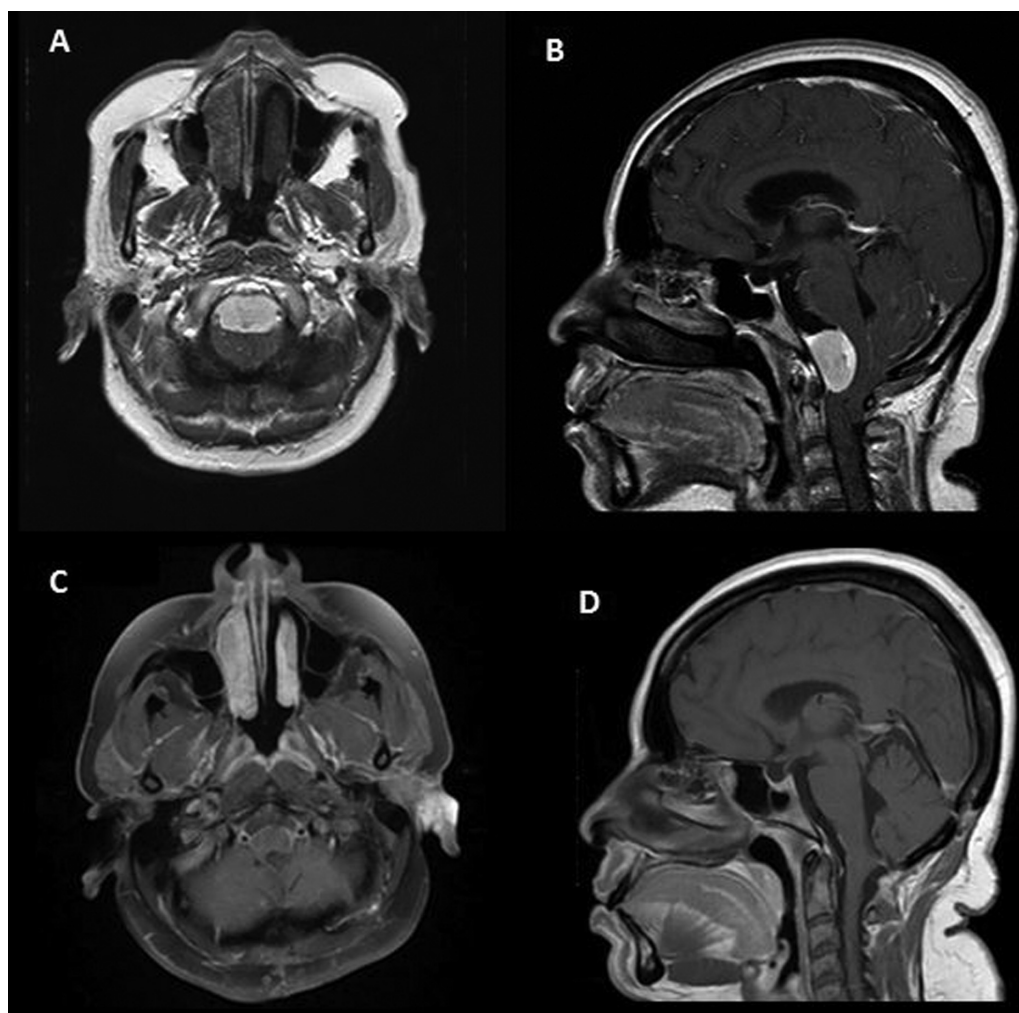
Preoperative (A) axial and (B) sagittal view T1 with gadolinium MRI showing a large anterior foramen magnum meningioma with close relationship with bilateral vertebral arteries. Postoperative (C) axial and (D) sagittal view T1 with gadolinium MRI showing complete tumor removal through an endoscope-assisted midline suboccipital subtonsillar approach. MRI, magnetic resonance imaging.
